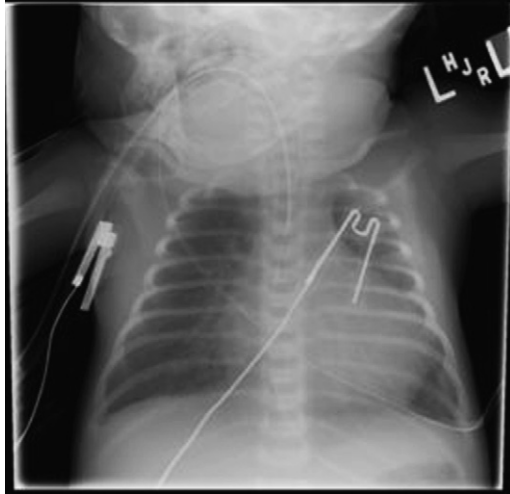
Chest radiograph of coarctation with cardiomegaly and pulmonary edema.
